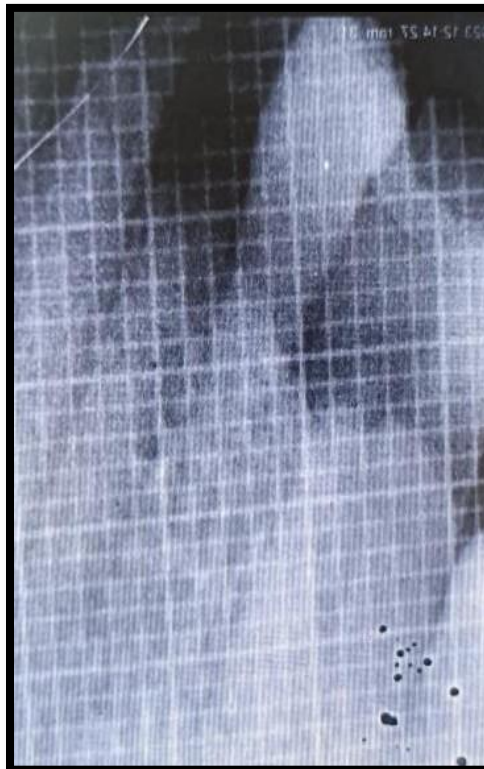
FIG NO 4 (xiii) Radiograph taken after 3 months
